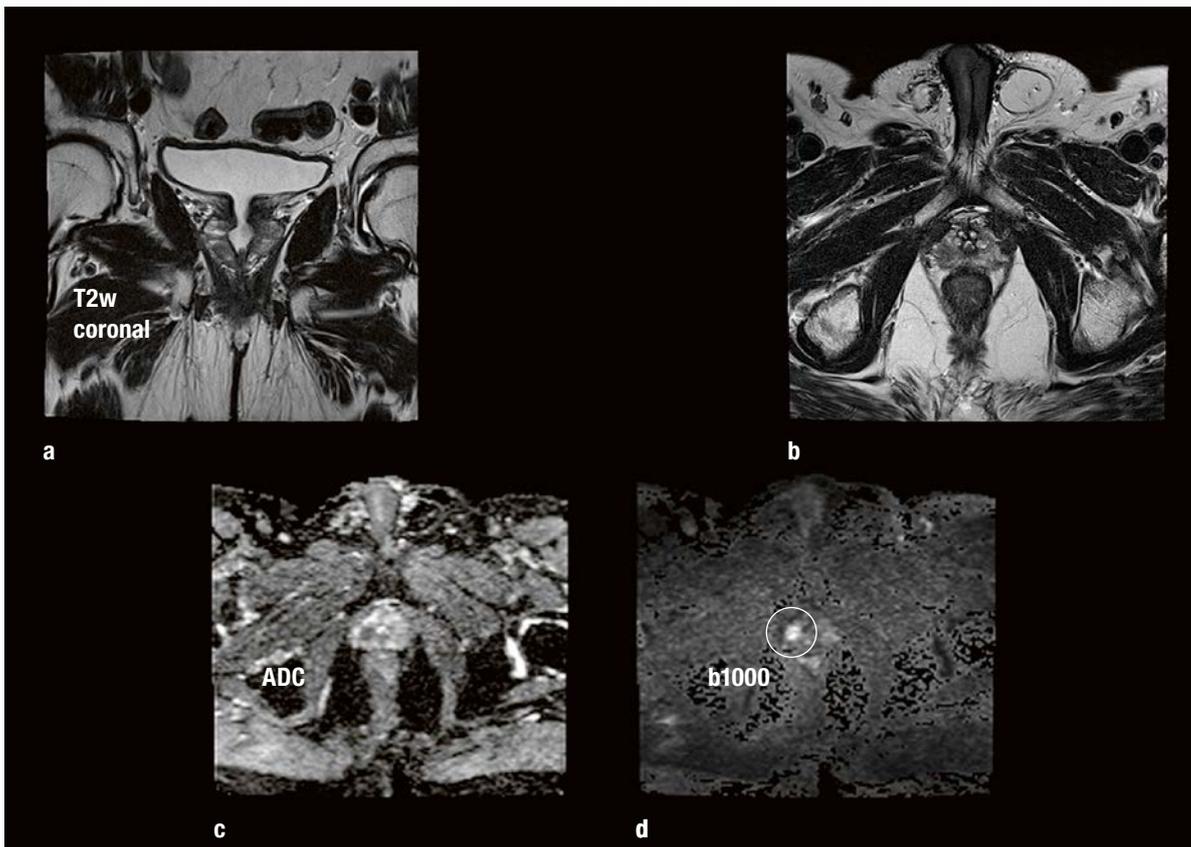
(a–d): T2w MRI in coronal (a) and axial (b) orientation, and DWI (c) corresponding ADC mapping (d) both in axial orientation.
